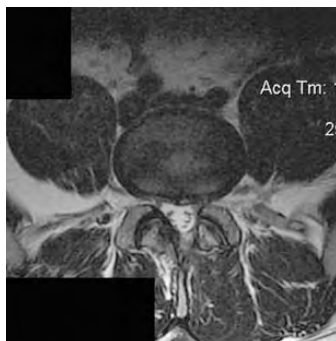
17 months postoperative T2 axial MRI with no appreciable herniation.
